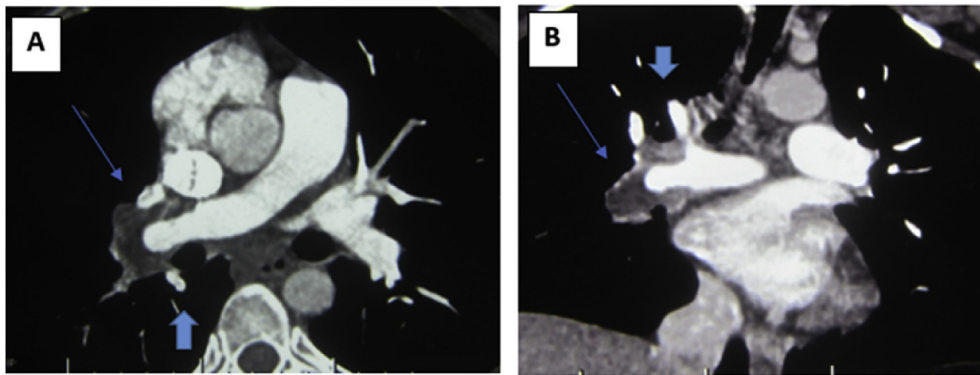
CT angiography of the pulmonary arteries (a) Axial view (b) Coronal view showing right main pulmonary artery aneurysm with circumferential thrombotic filling defect (Thin arrows) and ectatic adjacent bronchial arteries (Thick arrows).
